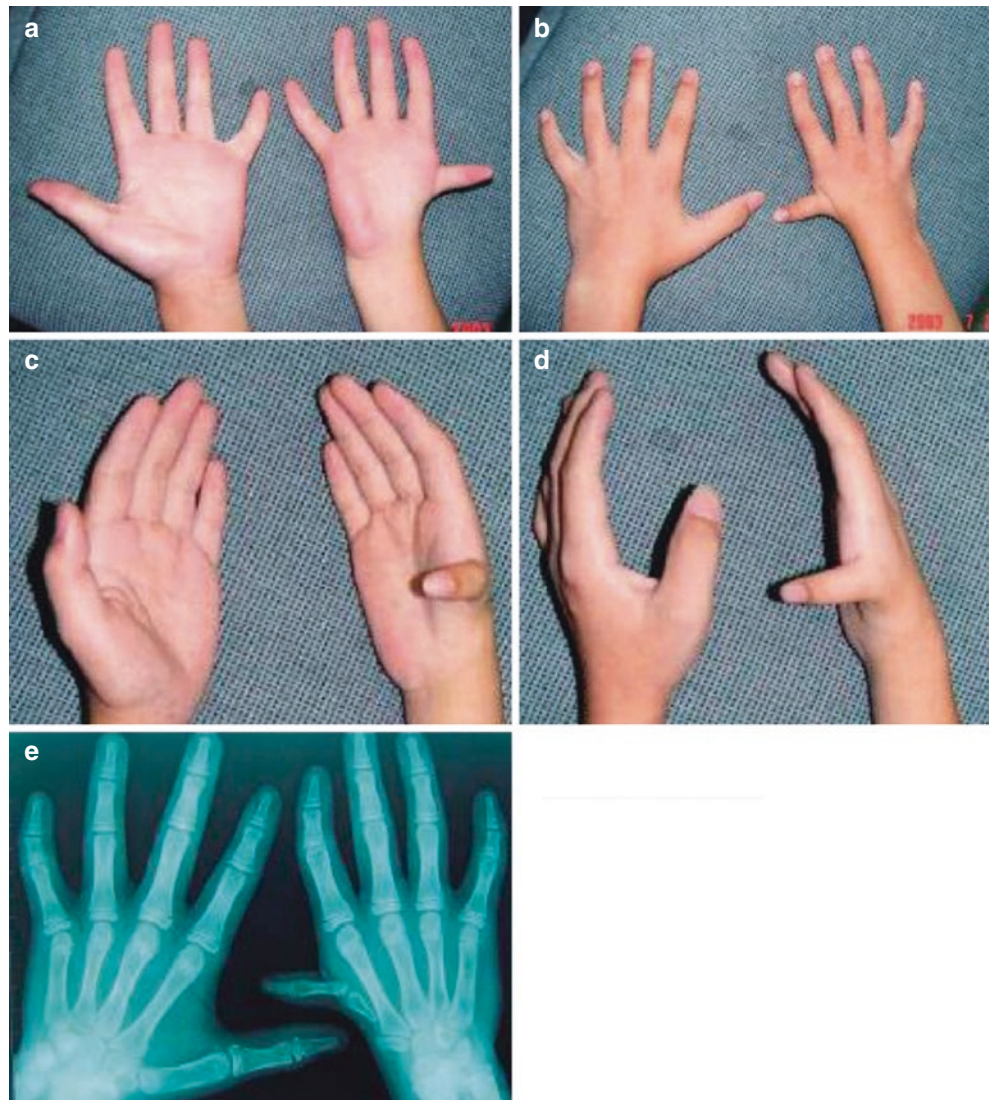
Case one: type IIIa thumb dysplasia of the right hand, type IIIb thumb dysplasia of the left hand. (a) Hand appearance. (b) X-ray findings
